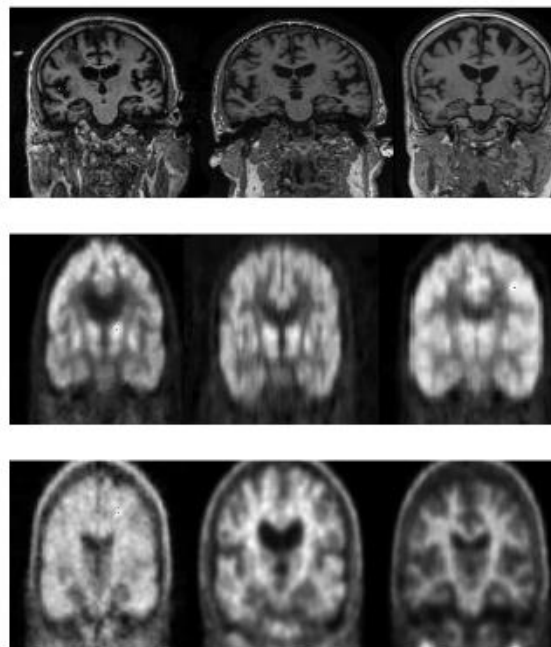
Scanned images of MRI
